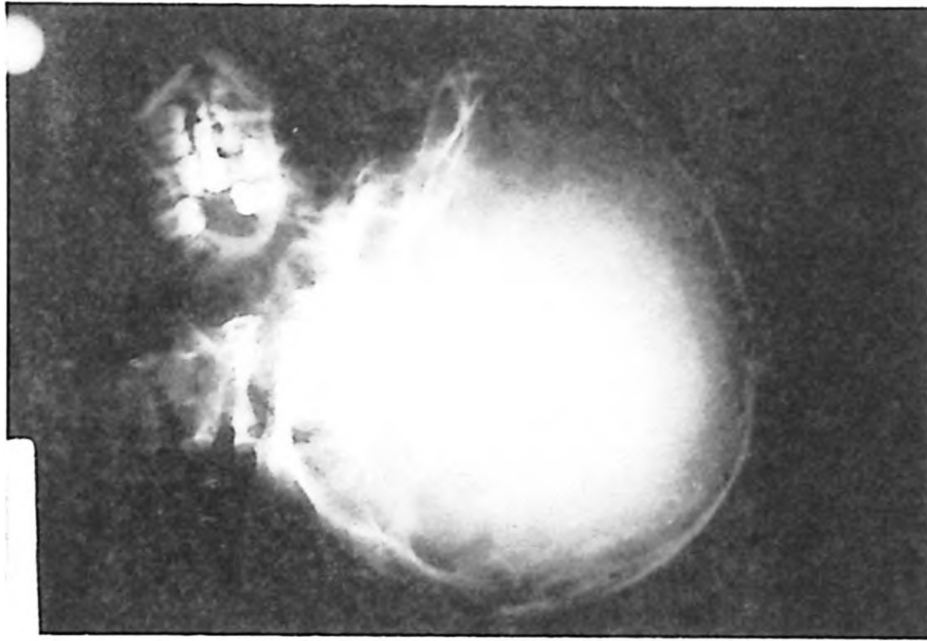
Skull X-ray: basilar impression and mildly hypoplastic mandible.
